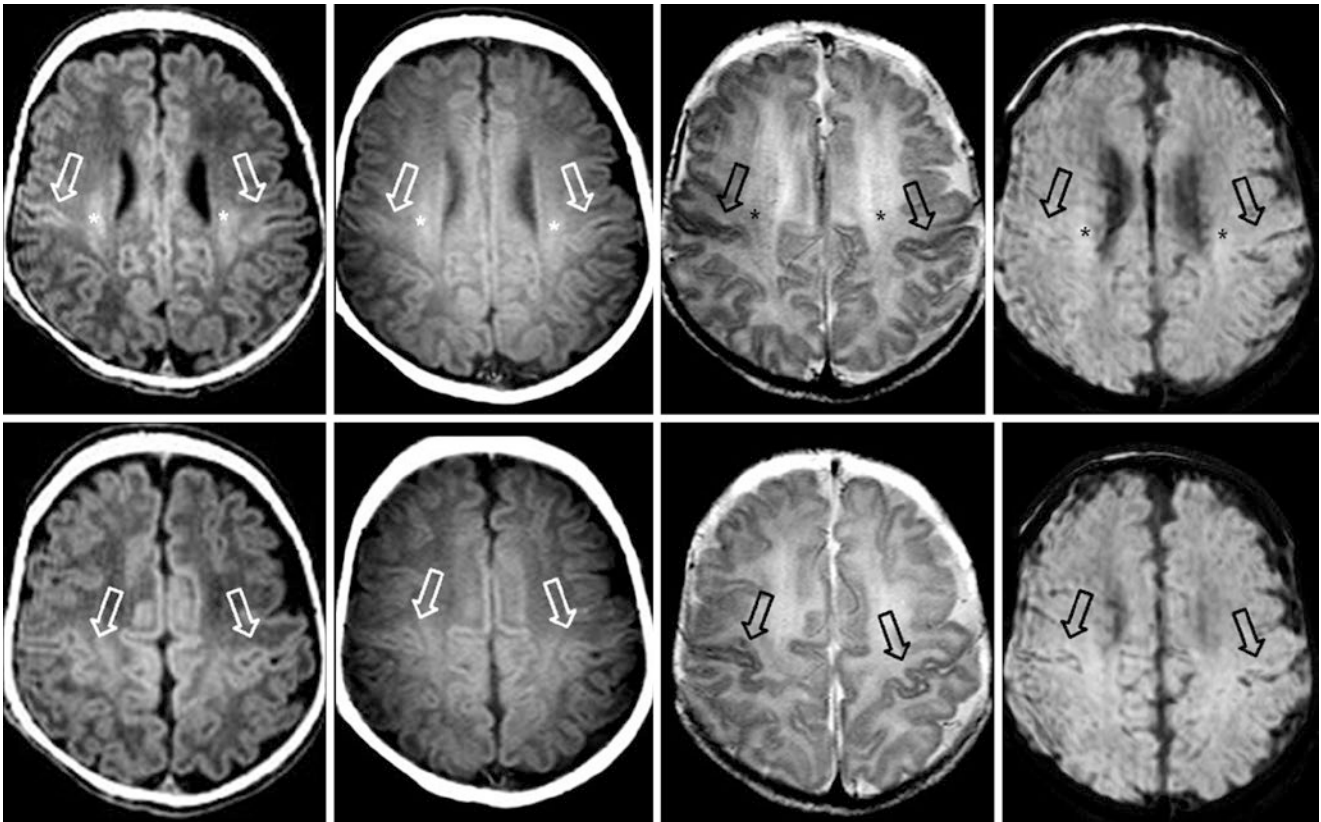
A 21-day-old term neonate had a normal 3T MRI with GE T1WI (left column), SE T1WI (left middle column), SE T2WI (right middle column), and SWI (right column). The CSTs within the corona radiata (asterisks) are bright on GE T1WI but less so on SE T1WI; the dark signal is less visible on SE T2WI. There is slight “T1
